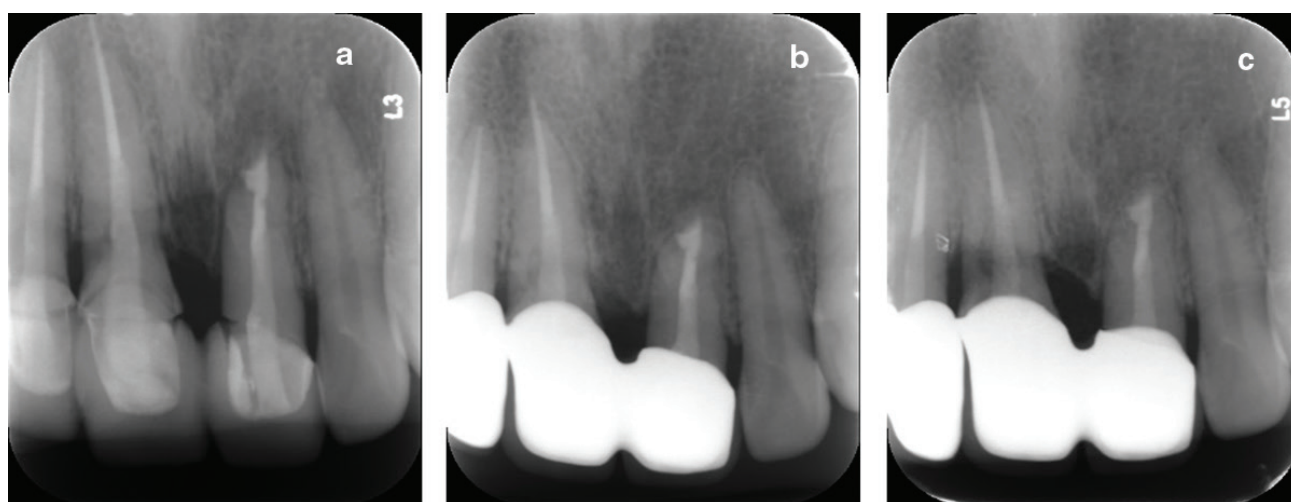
(a) A 12-month follow-up radiograph showed the healed periapical lesion and no sign of root resorption; (b) a 24-month follow-up radiograph showed no sign of root resorption; (c) a 48-month follow-up radiograph showed no sign of root resorption.
